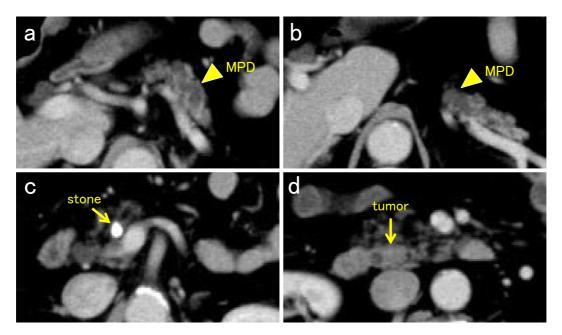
Abdominal contrast-enhanced CT shows severe atrophy of the pancreas with moderate dilation of the MPD (arrowhead) and a stone (arrow) in the MPD (a, b, and c). A slightly enhanced tumor (arrow) in the head of the pancreas that was missed at the time of diagnosis can be seen (d). MPD: main pancreatic duct
